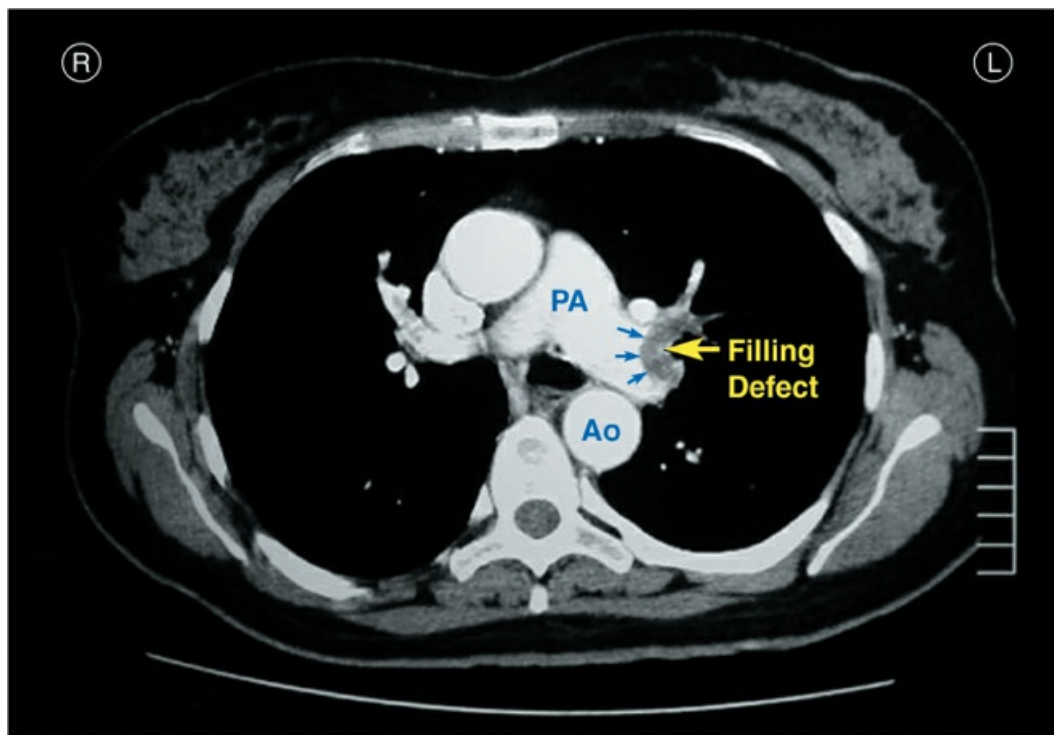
CT pulmonary angiogram showing a pulmonary embolus, which appears as a filling defect in the left main pulmonary artery. AO = aorta, PA = pulmonary artery. Image digitally retouched
